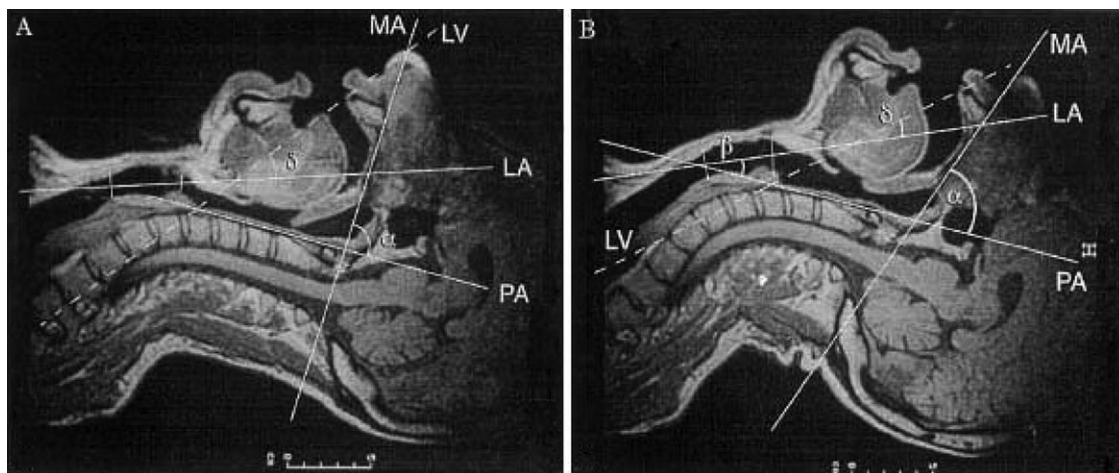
Mouth axis (MA), pharyngeal axis (PA), laryngeal axis (LA), line of vision (LV) in the two head positions; the effect of the ‘sniffing’ position. The magnetic resonance images are shown. (A) Neutral position; (B) simple head extension. (Reprinted with permission from the publication by Adnet and colleagues.¹¹)
